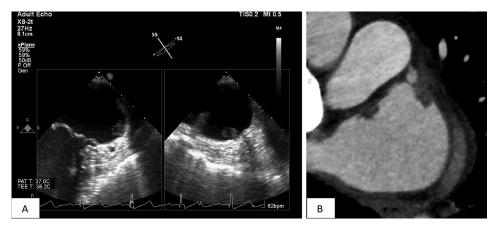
(A) Midesophageal two-chamber X-plane TEE view of left atrial appendage: an irregularly shaped heterogeneous mass attached to the remnant os of the left atrial appendage. (B) Computed tomography heart morphology study showing the two small left atrial masses.
